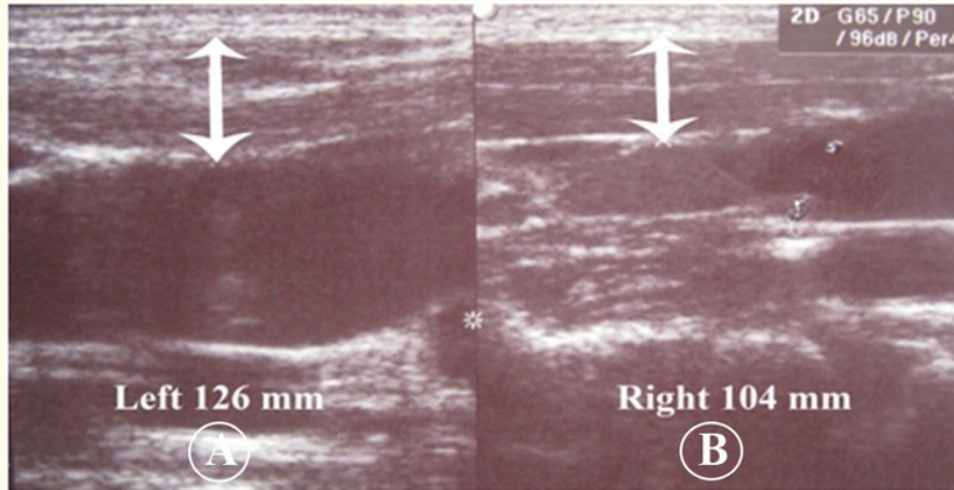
Ultrasound left CMT; Patient with left CMT: (A) Left SCM is thicker than (B) Right.
